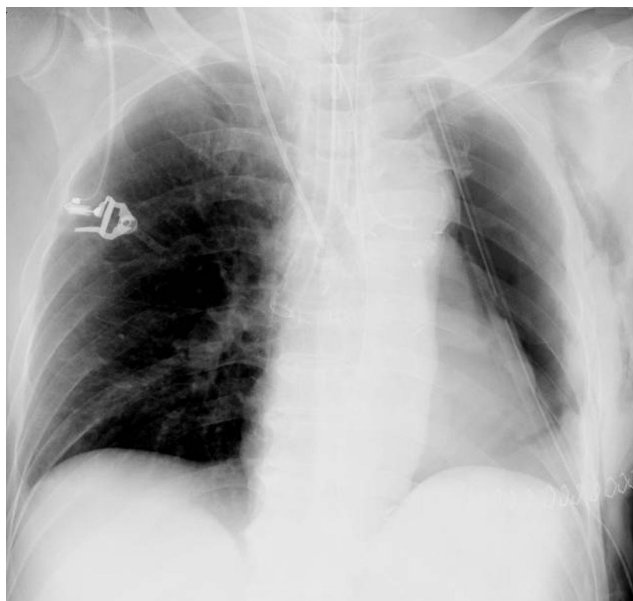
Chest x-ray image of case 1 just after the operation.
